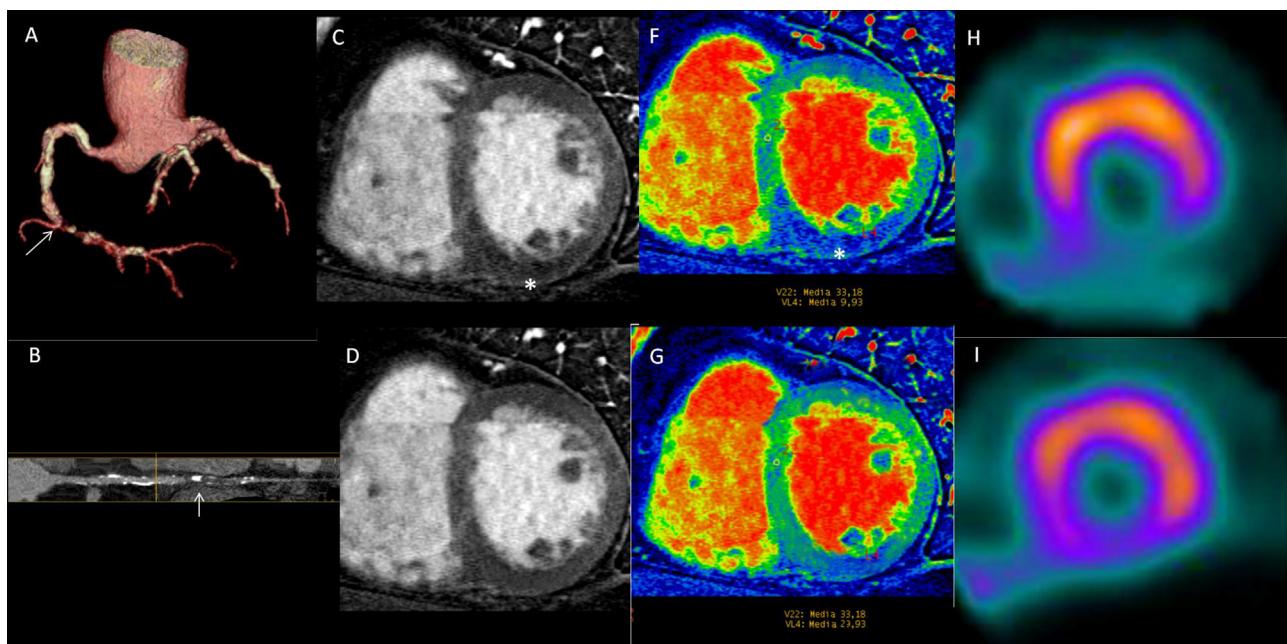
Myocardial perfusion imaging by dual energy CT (DECT) in a 53-year-old male with diabetes and hypertension as coronary risk factors, and chest pain, referred for myocardial perfusion imaging by single-photon emission computed tomography (SPECT). Computed tomography coronary angiogram depicts diffusely calcified coronary arteries, with total occlusion of the mid right coronary artery (arrow, panels A and B). Stress-DECT at monochromatic reconstruction (panels C and D) and color coded (panels F and G) demonstrate a perfusion defect at the inferior wall, with almost complete normalization at rest (asterisk, panels C–G). Stress–rest single-photon emission computed tomography confirm the findings.
